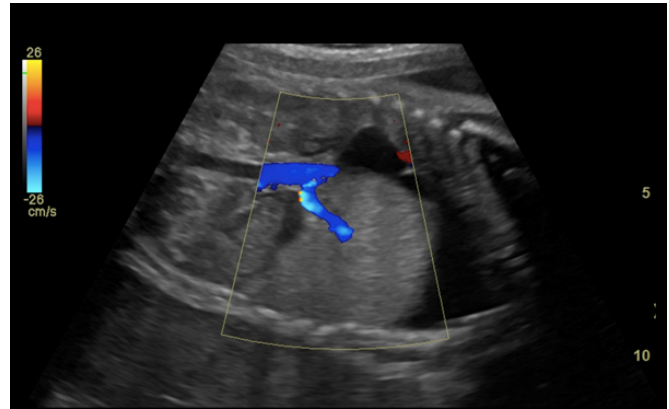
Colour Doppler study revealing feeding artery arising from the descending thoracic aorta.
